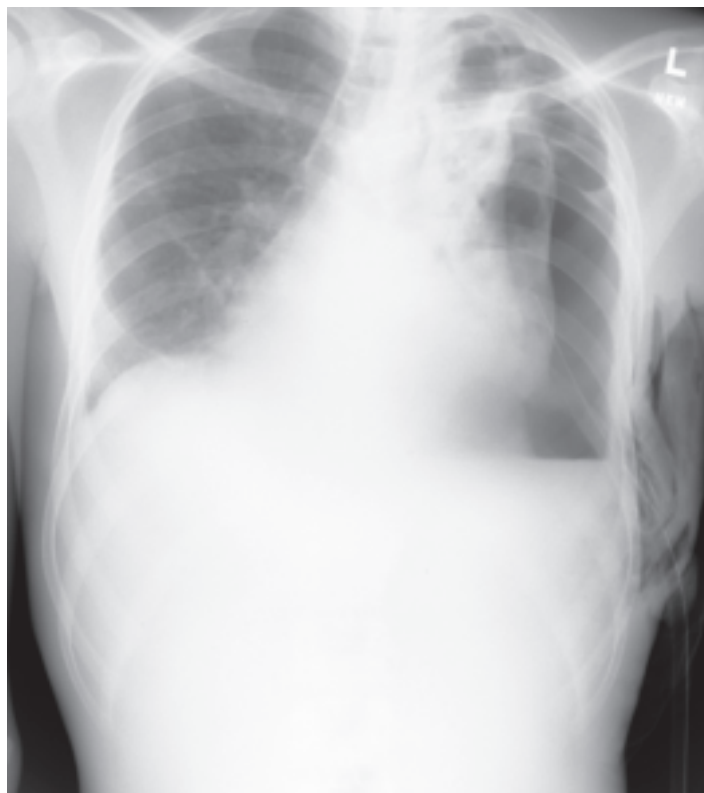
Chest radiograph after tube thoracostomy of a 32-year-old male with shortness of breath, with improvement in respiratory status and lung expansion with persistent left-sided air-fluid level and pneumothorax. (All patient images taken with permission of patient or accompanying guardian.)
